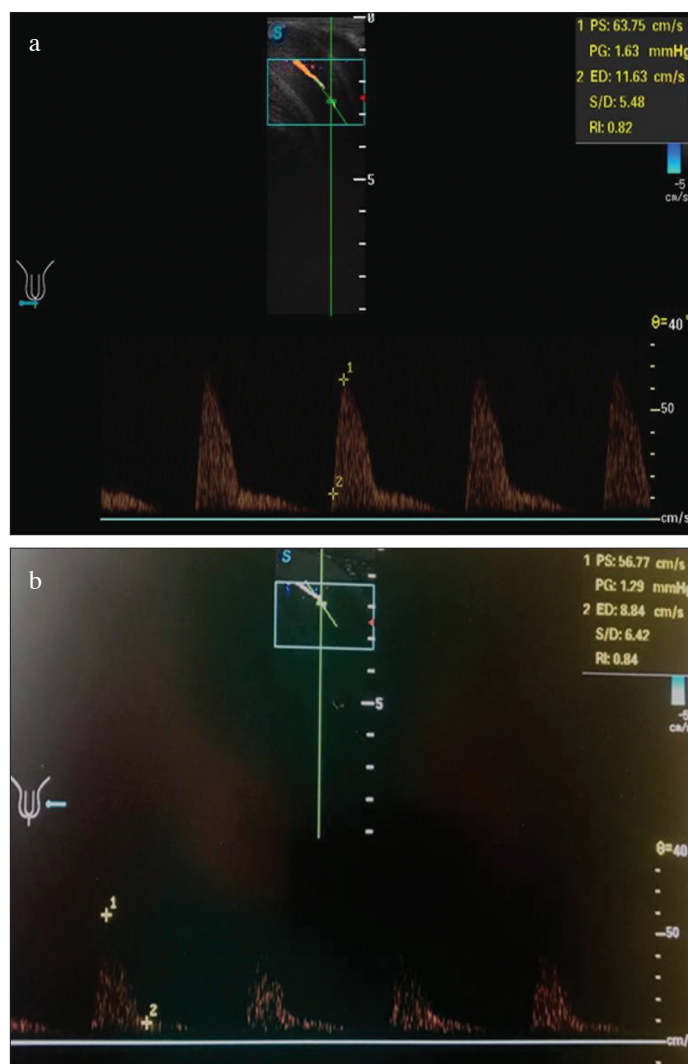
a, b. Postoperative day 4: penile Doppler ultrasound study shows high-velocity flow in the cavernosal arteries consistent with a high-flow state
